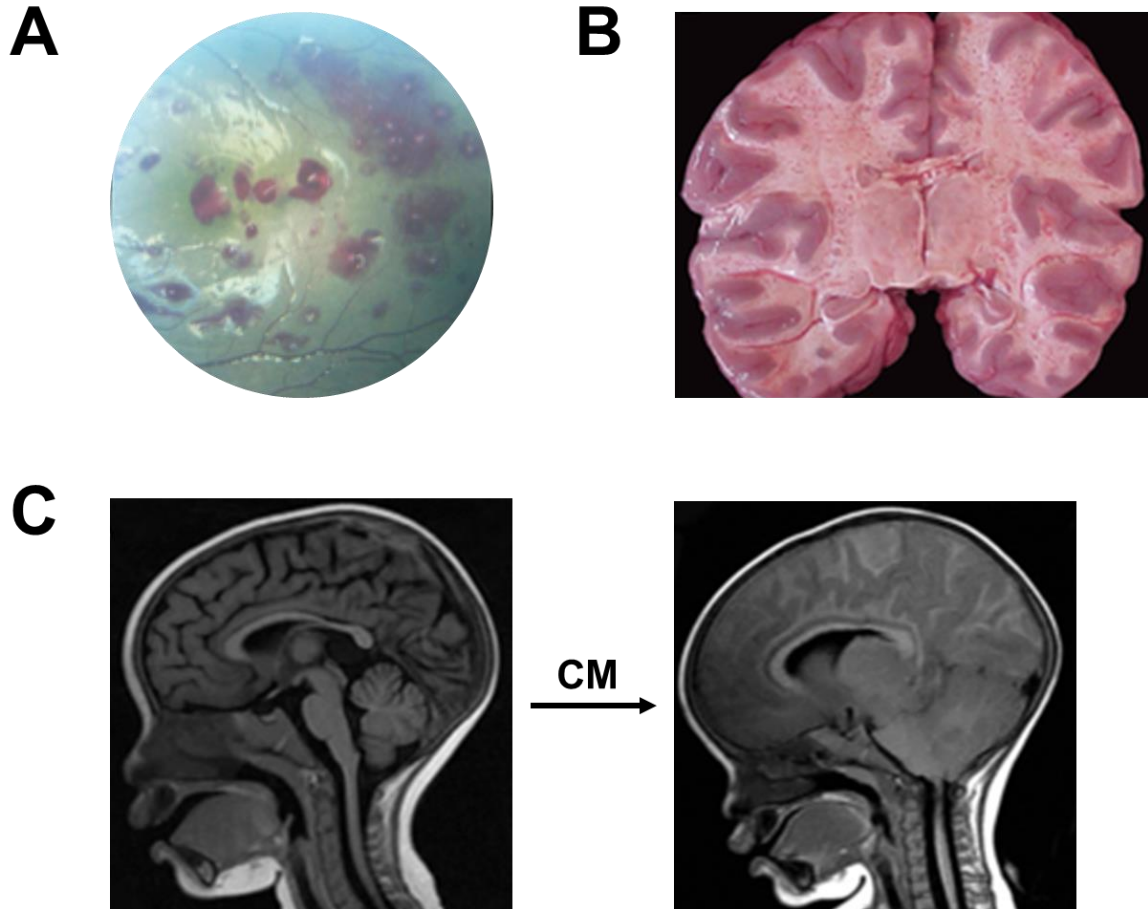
Manifestations of cerebral malaria (CM). (A) Funduscopy image depicting the white-centered hemorrhages of malarial retinopathy. Additional ocular findings in CM include retinal whitening and discoloration of blood vessels. (B) A feature of cerebral cortex pathology in CM is the presence of hemorrhages throughout the white matter. (C) Brain swelling in pediatric CM. Shown are representative MRI T2 images depicting the transition from no disease to severe CM. Key changes include flattening of the gyri, narrowing of the sulci, and downward herniation of the cerebellum with resulting crowding of the brainstem. Image reproduced with permission from Taylor and Molyneux (2014).⁷³
